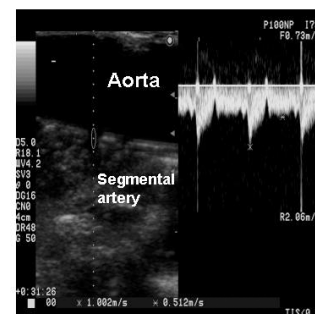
Segmental arteries are clearly identified with a 5MHz epiaortic scanning probe. The flow velocities of segmental arteries are measured with pulsed Doppler ultrasonography
